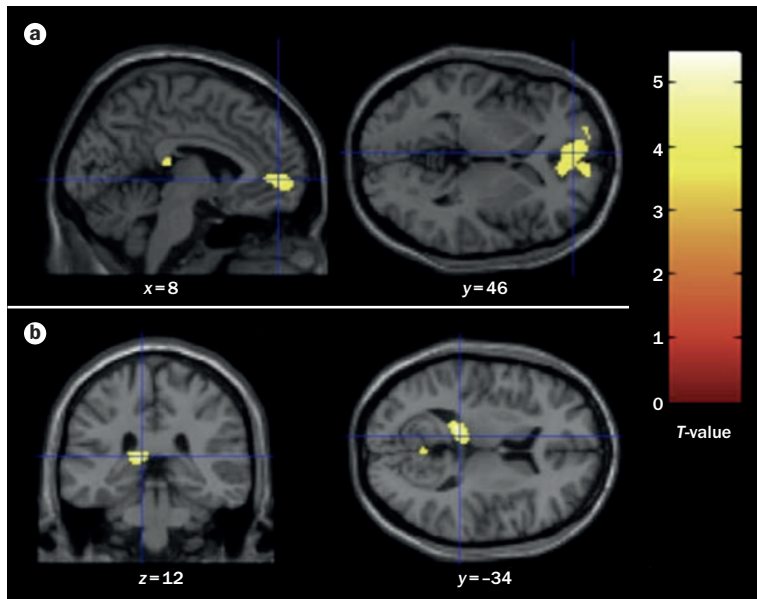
Regions of the brain in which healthy individuals have more activity than patients with fibromyalgia. Functional MRI of the brain during subjectively calibrated painful stimulation subtracting sensory stimulation. Clusters correspond to a | the rACC, and b | the pulvinar nucleus of thalamus. The exact anatomical locations (x, y, z) are given in MNI coordinates. Abbreviations: MNI, Montreal Neurological Institute and Hospital coordinate system; rACC, rostral anterior cingulate cortex. Reproduced with permission from Wolters Kluwer Health, Inc. Jensen, K. *et al.* Evidence of dysfunctional pain inhibition in fibromyalgia reflected in rACC during provoked pain. *Pain* 144, 95–100 (2009).⁴⁸
